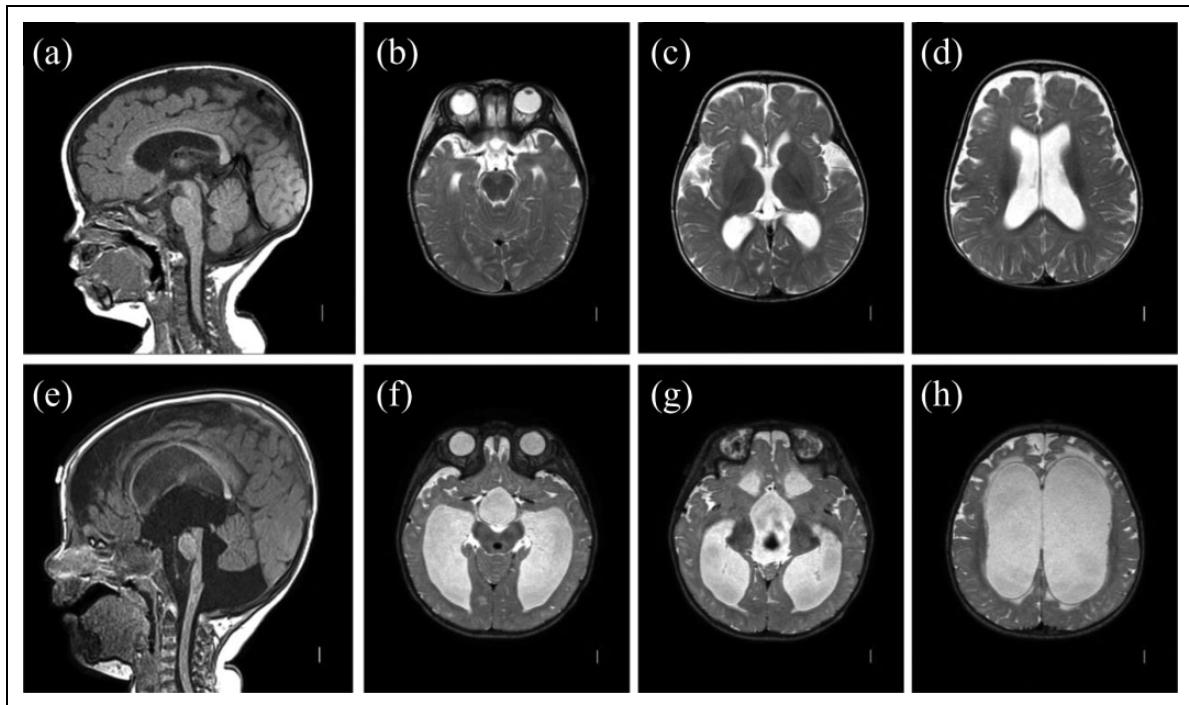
Communicating hydrocephalus. (A-D) Mild idiopathic communicating hydrocephalus. Sagittal T1 MRI image (A) showing open aqueduct and absence of posterior fossa crowding. Axial T2 images (B-D) showing rounded, mildly dilated ventricles with generous extra-axial space. (E-H) Severe idiopathic communicating hydrocephalus. Sagittal T1 image (E) showing enlarged aqueduct, fourth ventricle, and excess fluid within the posterior fossa. Axial T2 images (E-H) demonstrate marked ventriculomegaly with transependymal flow.
